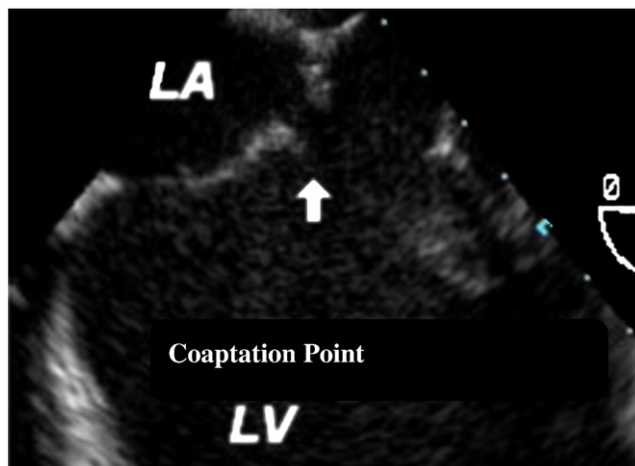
Transesophageal echocardiographic view of inadequate coaptation due to annular dilatation and leaflet tethering. LA = left atrium, LV = left ventricle.
